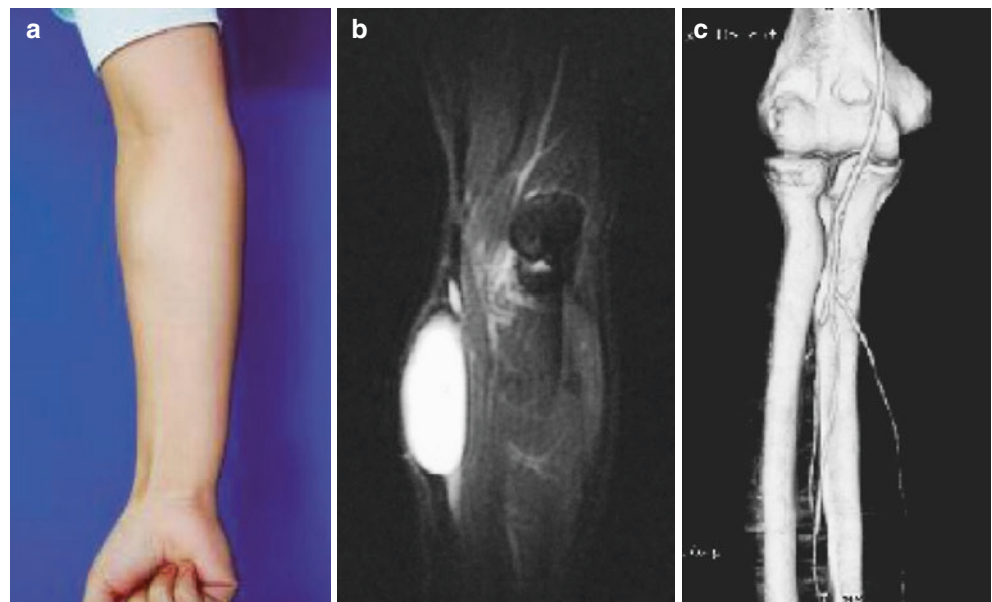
Lymphatic malformation in the right forearm. (a) Bulging mass of the right forearm with a hard texture. (b) MRI indicates that foci in the T2-weighted images present homogeneous and well-defined high signals. (c) Computed tomographic arteriography cannot display the foci
